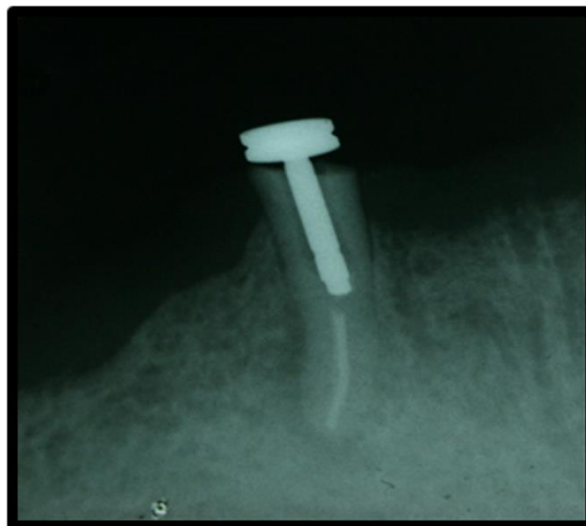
Precementation radiograph.
